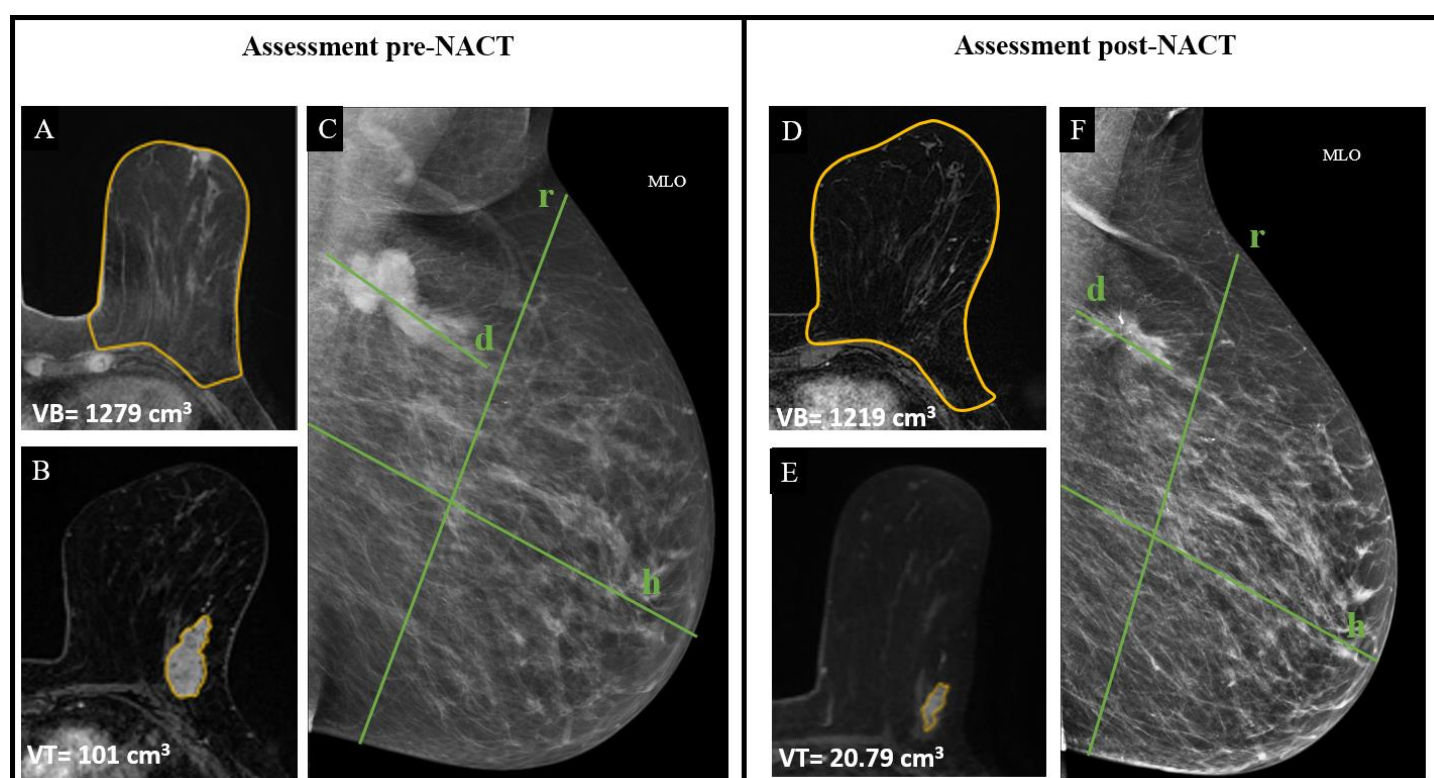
Definition of Prediction of the Excised Breast Area (PEBA). The volume of the breast is calculated on the axial images with MRI (A. pre-NACT and D. post-NACT); the tumor volume was instead measured by surrounding the tumor with MRI (B. pre-NACT and E. post NACT). While in the evaluation of PEBA with RX, "r" describes the diameter of the mammary gland; "h" mammary gland height. "d" maximum length of the lesion. Vb= Volume of breast and Vt=volume of tumor (C. pre-NACT and F. post-NACT).
